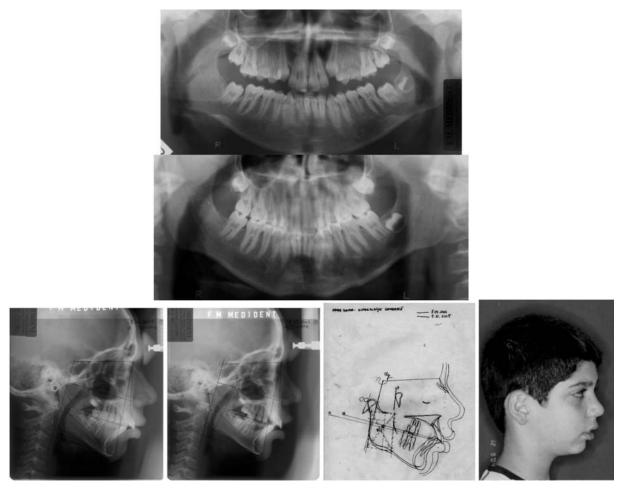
Patient A. T., male, orthopantomograms and lateral skull radiographs at the ages of 11 years and 12 years and 3 months; tracings superimposition, profile aspect
